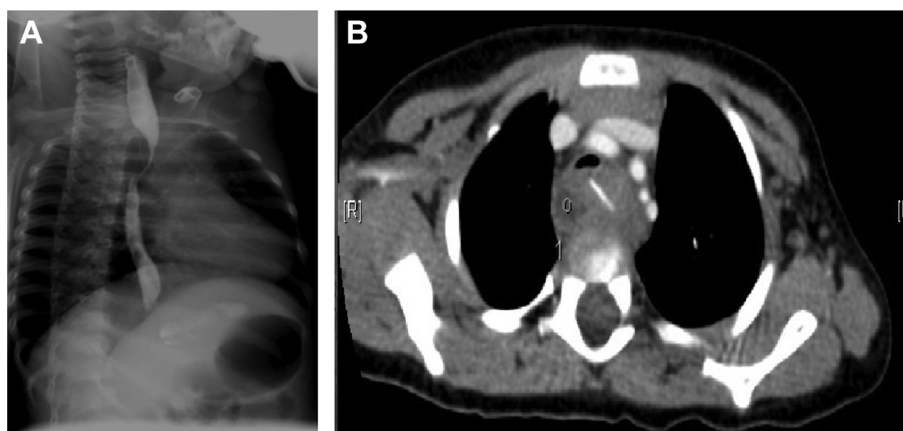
(A) Upper GI contrast swallow study demonstrating smooth narrowing with anterior displacement of a short segment of the upper thoracic esophagus; and (B) CT scan cut immediately above the carina shows prevertebral soft-tissue swelling and a linear high-density object within the swelling. The trachea is displaced anteriorly. CT = computed tomography; GI = gastrointestinal.
